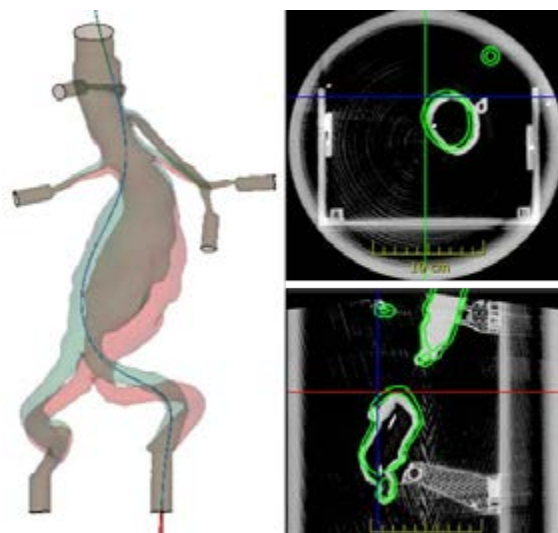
FEA results: deformed configuration with fully inserted guidewire (green) vs initial (red), left side. Experimental (CBCT, grey) vs FEA results (green) in axial and sagittal planes, right side.
